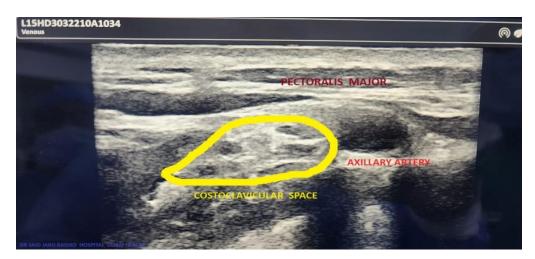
Sonographic anatomy of the Costoclavicular Space Block
